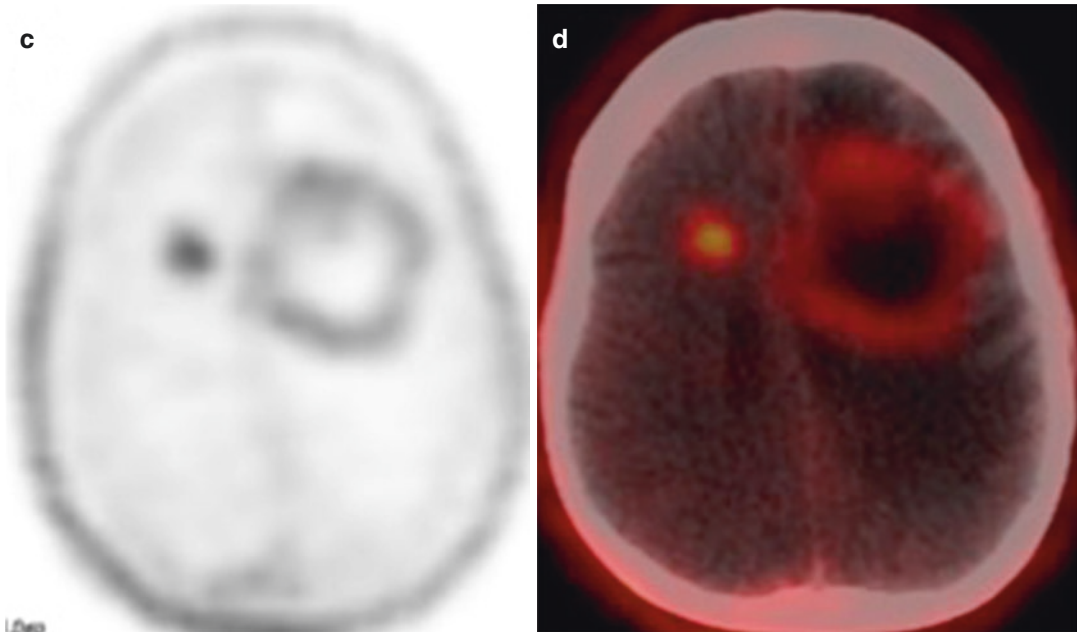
A 67-year-old elderly male, case of WHO Grade III, anaplastic astrocytoma–pericallosal location in midline anteriorly, received radiotherapy followed by concurrent and adjuvant TMZ, was asymptomatic for 1 year, after which, on follow-up MRI (a, arrow), ill-defined T1-post-contrast enhancement was seen in anterior genu of corpus callosum (arrow), which was reported as post-treatment changes as it showed hypoperfusion.
